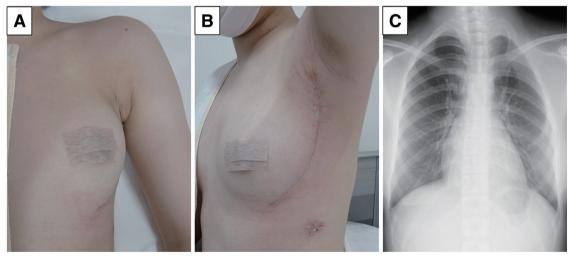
(A) Front view and (B) axillary view of the chest wall showed that an axillary incision line along the mammary line provides cosmetic advantages. (C) Postoperative chest X-ray showed the well-expanded left upper lung.
